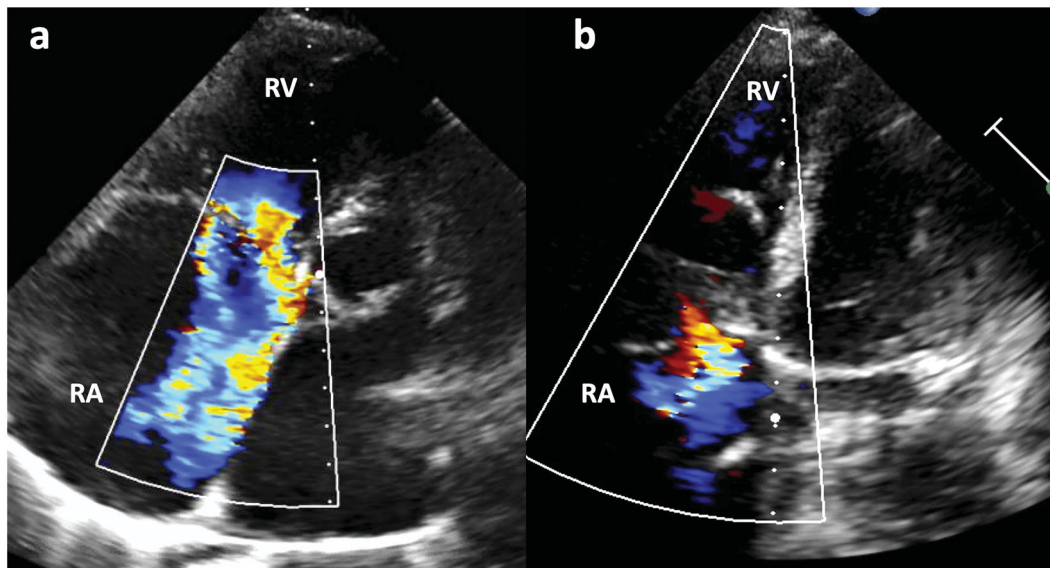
Transthoracic echocardiography before (a) and after (b) Triclip placement. RV: right ventricle; RA: right atrium.
